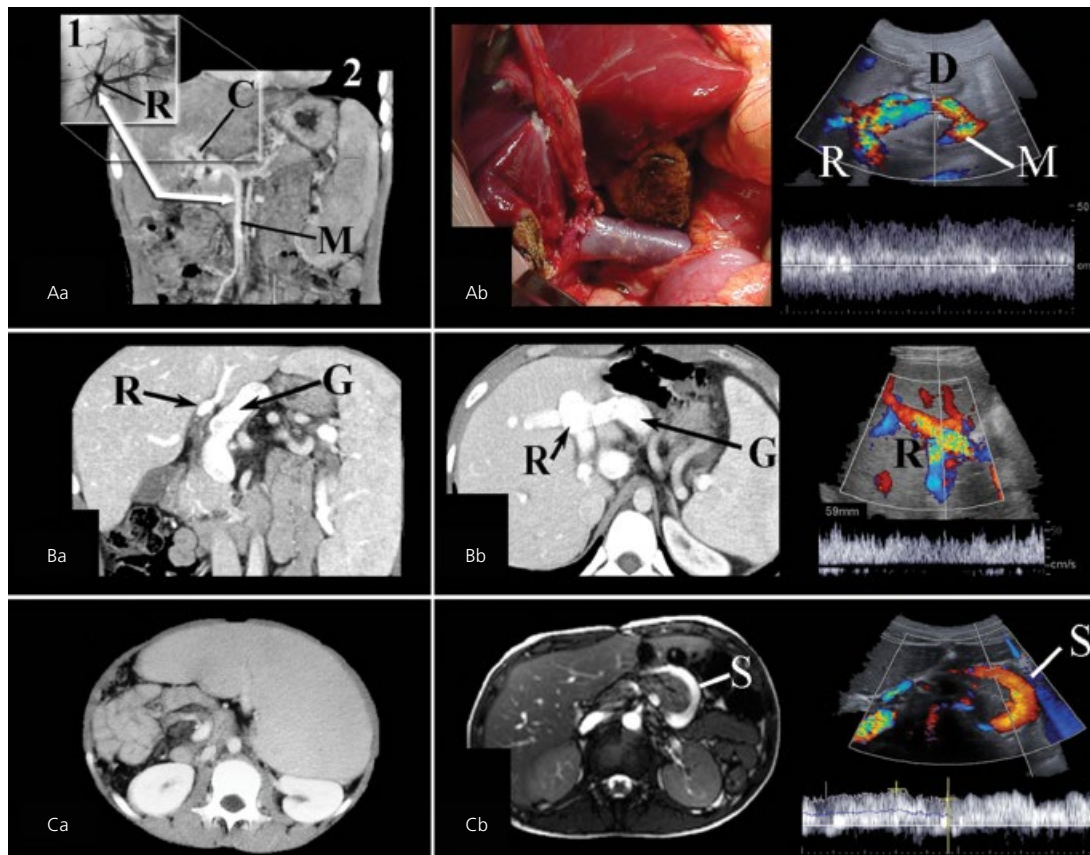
Management of extrahepatic portal hypertension by bypasses into the Rex recessus (R). (A) Bypass from the superior mesenteric vein (M) with a standard technique: 1, retrograde portography showing that the intrahepatic portal system and the Rex recessus are patent; 2, CT reconstruction. (B) Bypass from the gastric vein (G) in a patient with a favorable anatomy consisting of a large gastric vein sitting close to the Rex recessus. (C) Bypass using the splenic vein (S) in a teenager complaining of a huge splenomegaly (Ca) and who underwent a splenectomy with spleno-Rex bypass (Cb). (Aa, Ba, and Ca are preoperative views; Ab, Bb, and Cb are operative and postoperative views.) C, cavernoma.
